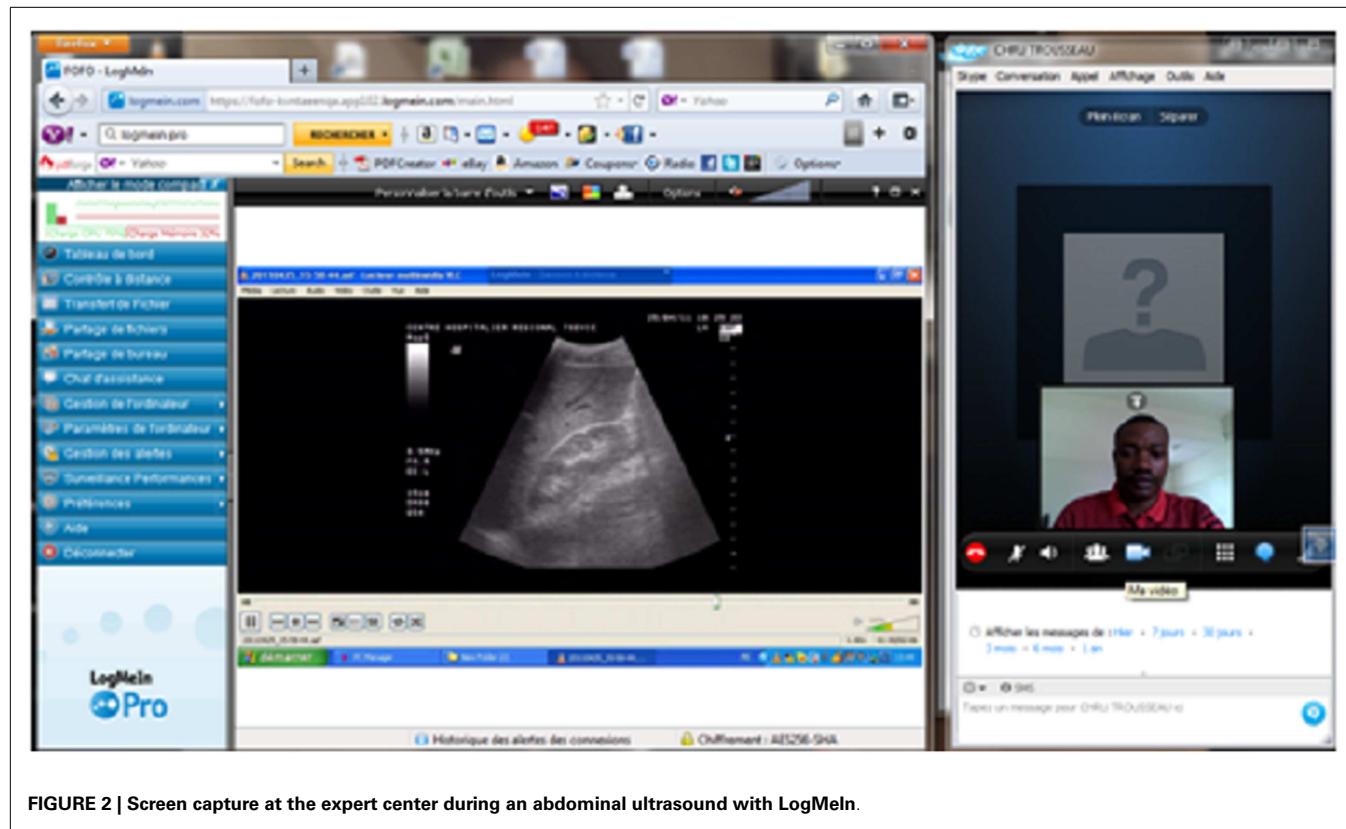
Screen capture at the expert center during an abdominal ultrasound with LogMeIn.
